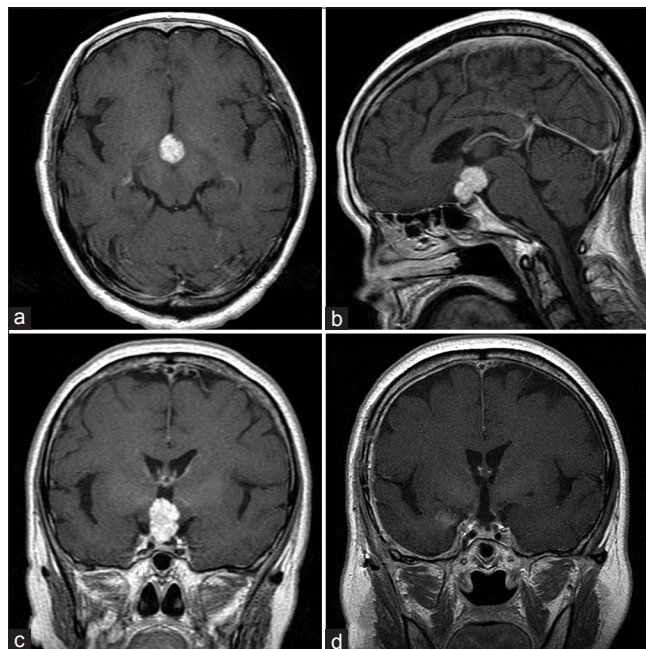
The pre and postoperative magnetic resonance images (MRI) of case 7. (a) Axial image of gadolinium (Gd)-enhanced T1-weighted MRI. Solid well-enhanced tumors exist in the interpeduncular cistern. (b) Sagittal image of Gd-enhanced T1-weighted MRI. The tumor exists in the supradiaphragmatic space. (c) Coronal image of Gd-enhanced T1-weighted MRI. (d) Postoperative coronal image of Gd-enhanced T1-weighted MRI. The tumor has been removed completely
